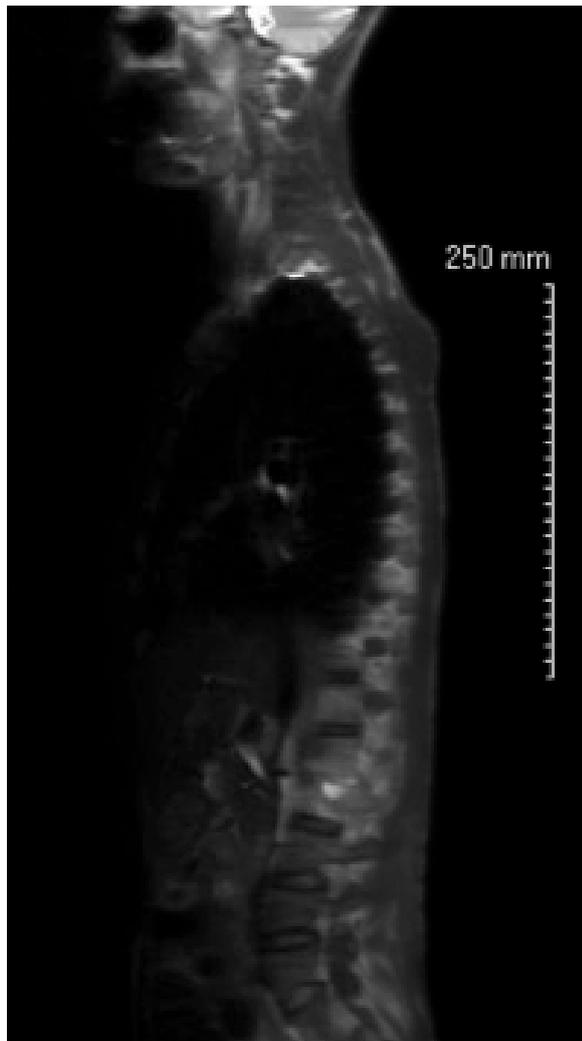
MRI spine showing prominent Psoas Abscess
